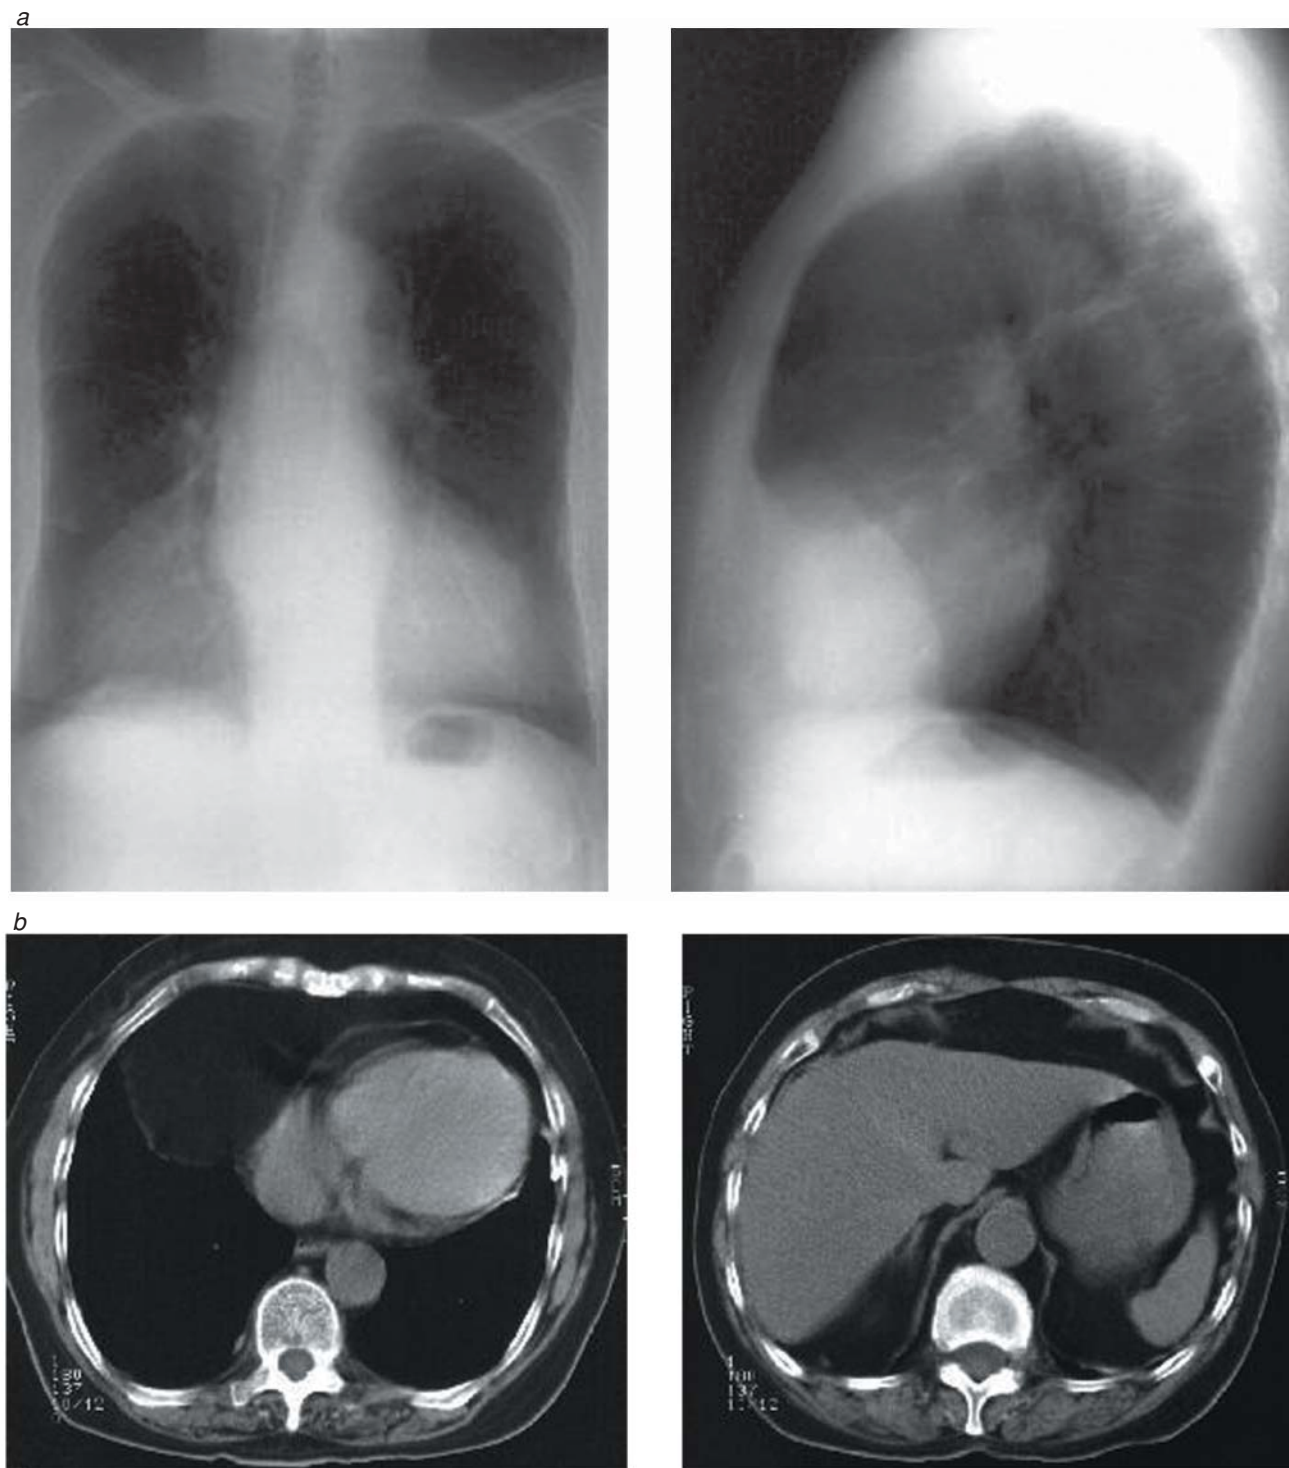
Repair of Morgagni hernia. The differential diagnosis of a cardiophrenic-angle mass includes pericardial fat, a lipoma, a pericardial cyst, a Morgagni hernia, and a thymoma. Shown are (a) chest x-rays and (b) chest computed tomographic scans from a 33-year-old man with an incidental finding of a Morgagni hernia.
